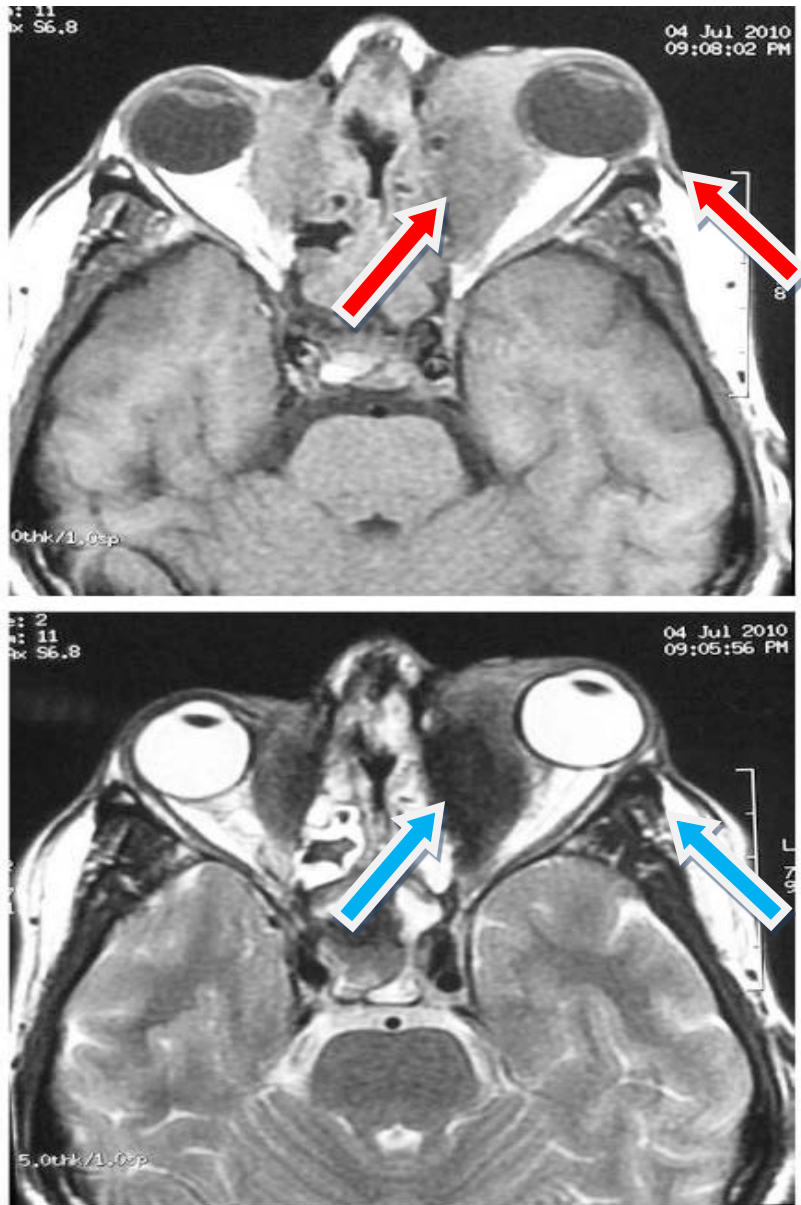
MRI Orbital magnetic resonance imaging in GPA showing heterogenous bilateral orbital mass lesions adjacent to the medial walls. The lesions have moderate intensity, similar to muscle on axial T 1-weighted (top, red arrows) and low intensity on axial T 2-weighted images (below, blue arrows)
